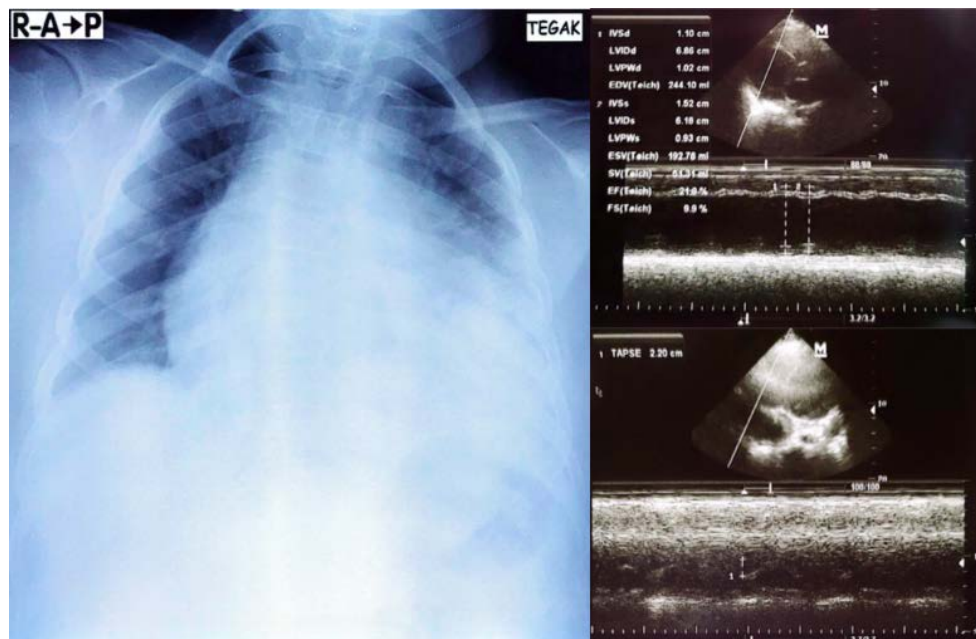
Chest X-ray showing cardiomegaly and echocardiography showing LA and LV dilatation, with global hypokinesia and 21% ejection fraction.
